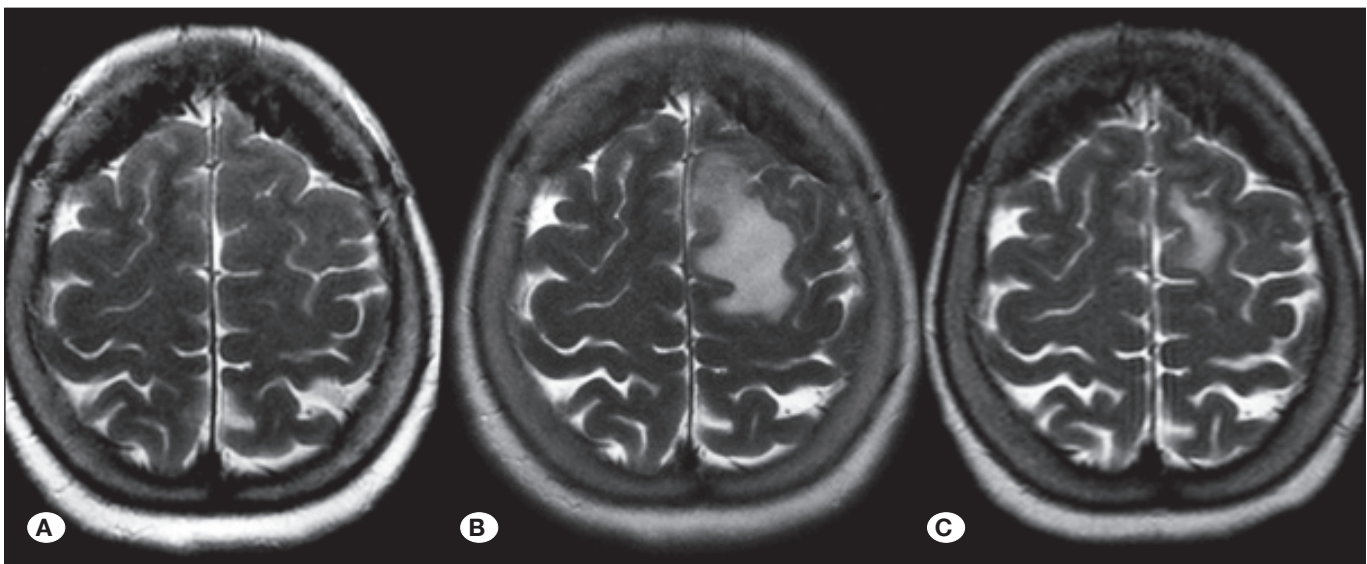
T2W axial MRI images obtained before Gamma Knife treatment (A), post-treatment at 4 months (B), and at 11 months (C).
